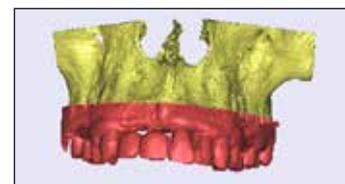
STL model of the CBCT united with 3D scanned model.
